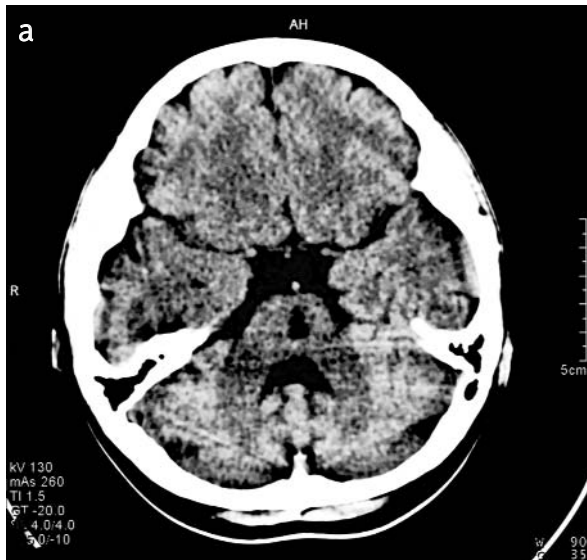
CT scan of the brain showing two hypodense focuses in: a) central part of the pons (biggest) and b) left cerebral peduncle (smaller)
